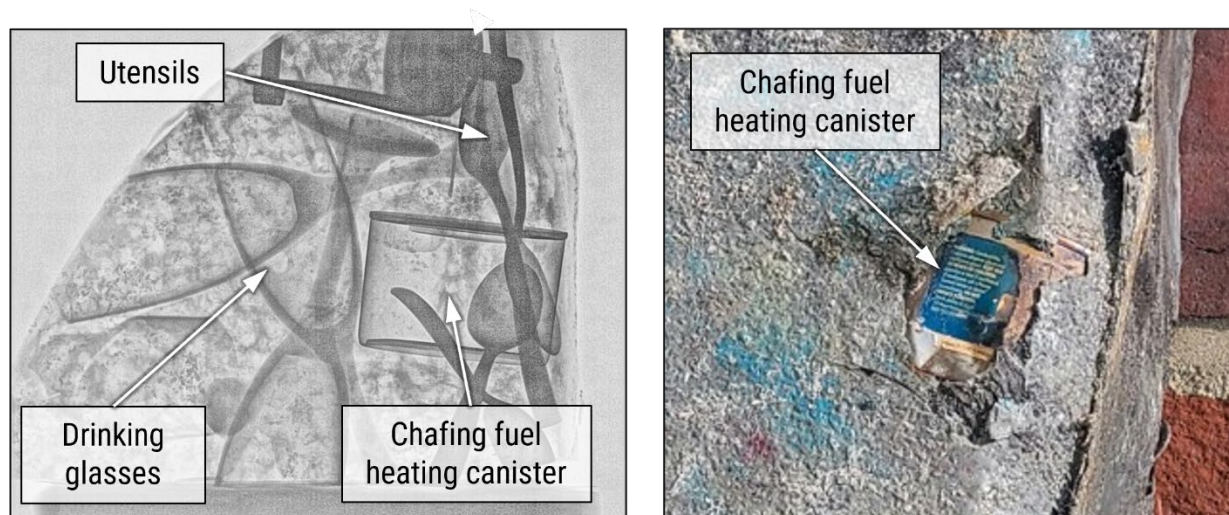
Left to right: X-ray image of debris removed from the *Spirit of Boston* deck 1 wait station showing chafing fuel heating canister. Closeup of chafing fuel heating canister found in the same debris. (Background sources: ATF, Coast Guard)
